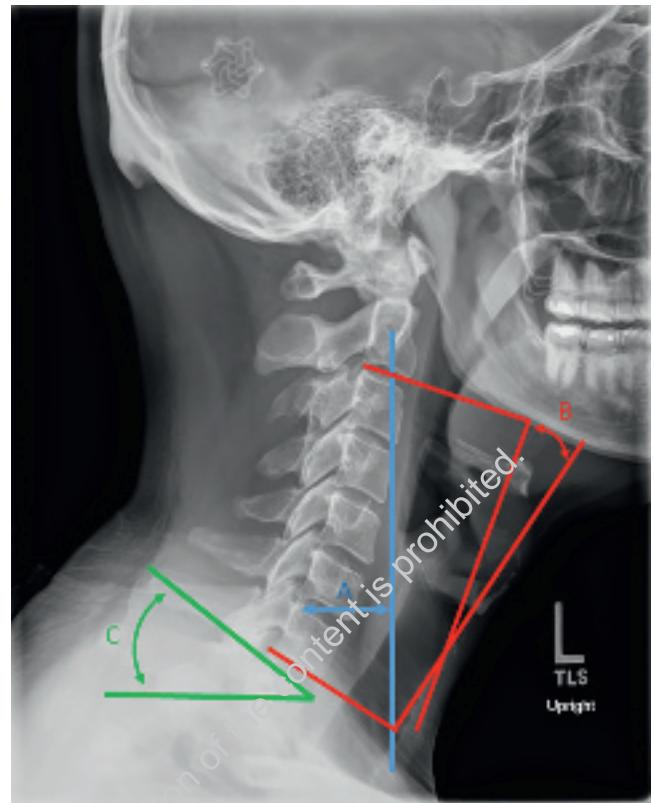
Lateral digital radiograph demonstrating parameters used to assess cervical spine sagittal alignment including C2-C7 sagittal vertical axis (A), cervical lordosis (B), and T1 slope (C).
